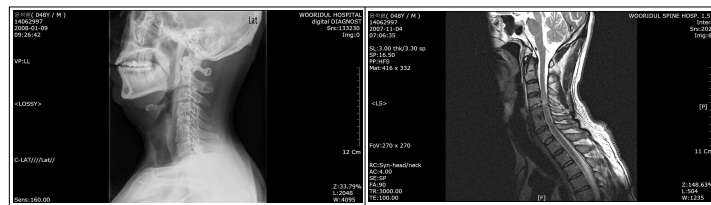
MRI after operation of PCD Cx4–5
